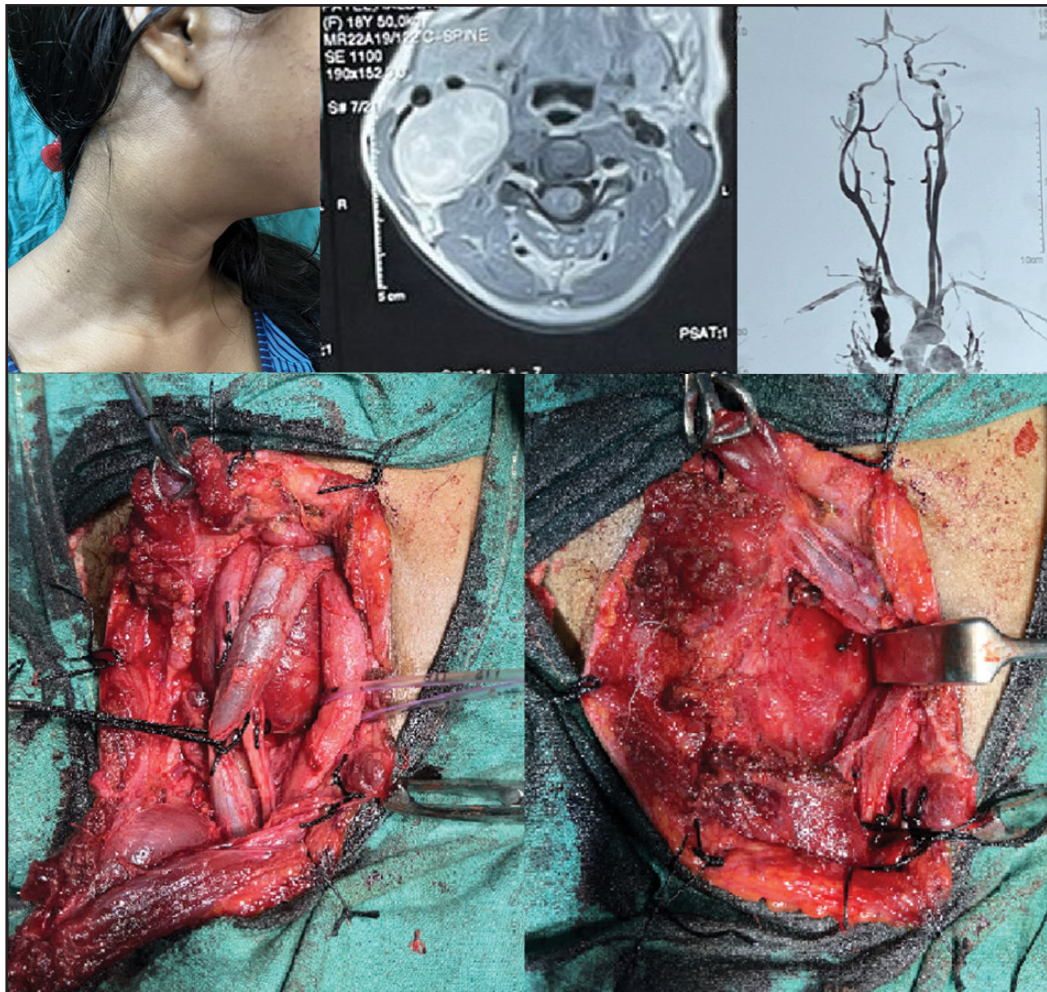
(left to right, top row) 3a. Clinical Picture of the patient; 3b. Contrast enhanced MRI of lesion at the level of supraglottis in axial section; 3c. CT angiography of the lesion in coronal view; (bottom row) 3d., 3e. Intra operative picture showing the lesion after dissection and after removal.
